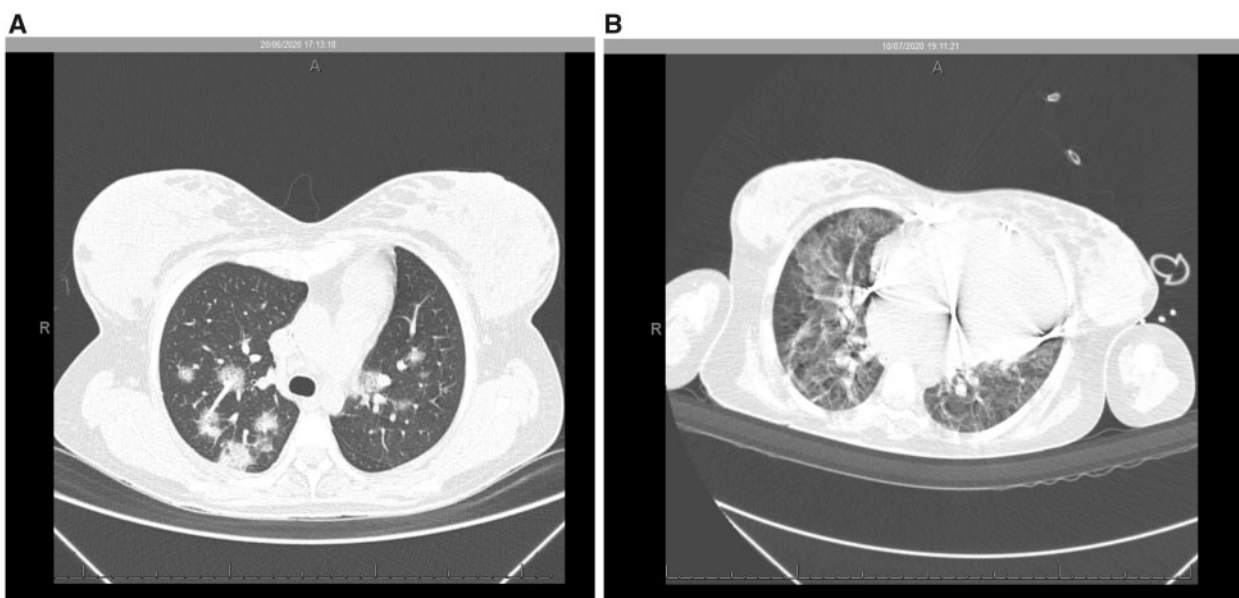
Non-contrast chest computed tomography scan demonstrated multiple ground-glass opacities associated with thickening of interlobular septal and thin interlaced reticulum, with bilateral multifocal distribution and peripheral and posterior predominance, with extent of lung involvement estimated visually of <50% (A). Nineteen days after a positive COVID-19 test, an increase was observed in multiple ground-glass pulmonary opacities, in addition to sparse foci of consolidation, with bilateral multifocal distribution, the extent of pulmonary involvement, estimated visually to be >50% (B).
